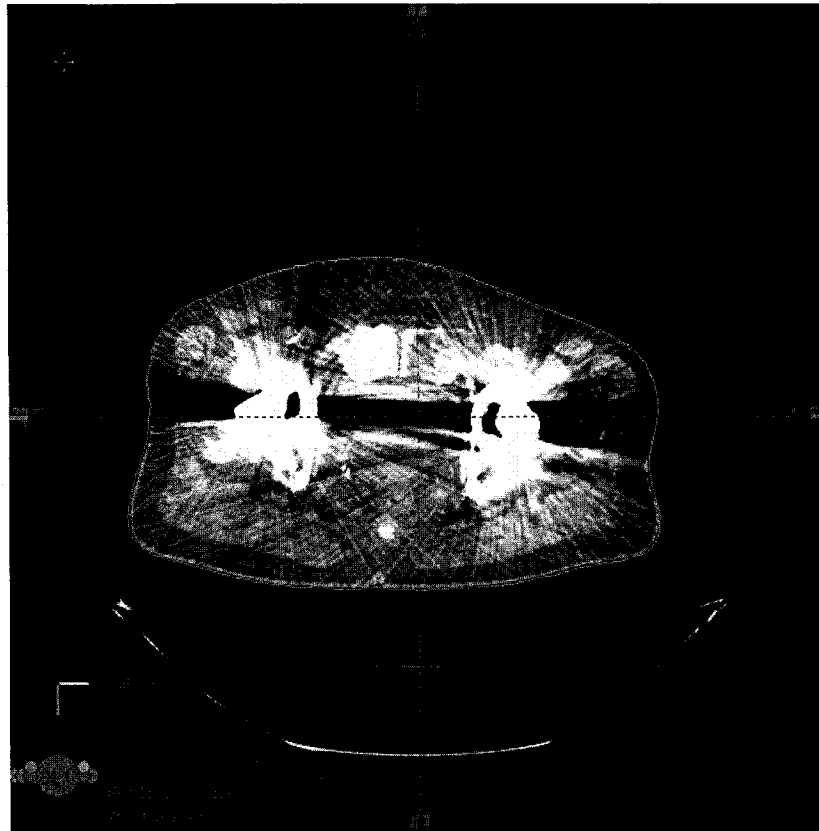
Diagnostic CT image of a patient with bilateral hip prostheses demonstrating the detrimental effect of metal in filtered backprojection.
